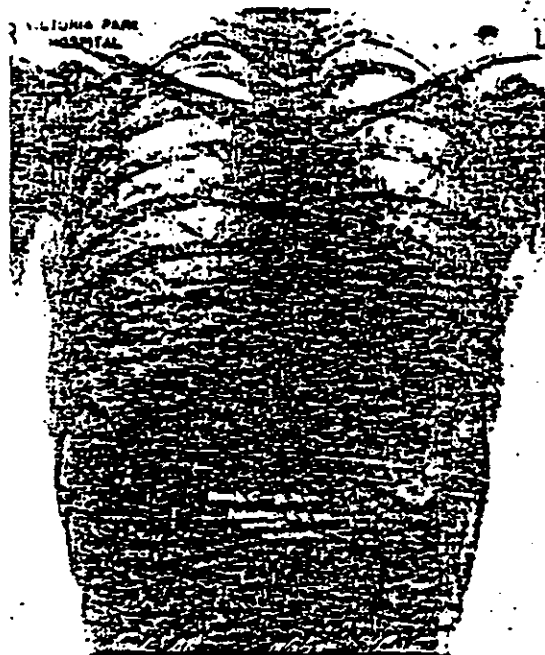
Roentgenogram of chest of asbestos worker: exposed for nine years: duration of symptoms, three years.
